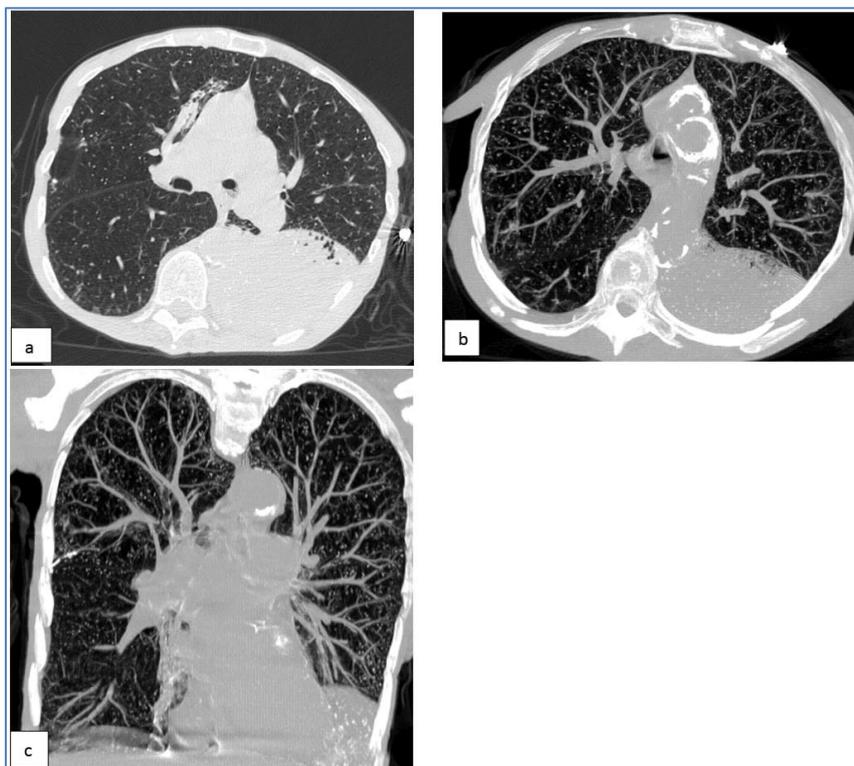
A thoracic computed tomography in axial (A and B) and frontal (C) sections, in lung window, in maximum-intensity-projection (MIP) (B and C) showing an alveolar consolidation of left lower lobar with centrilobular periarteriolar micronodules, making a discreet tree-in-bud pattern in some places, related to her disease (Intravascular talcosis).
